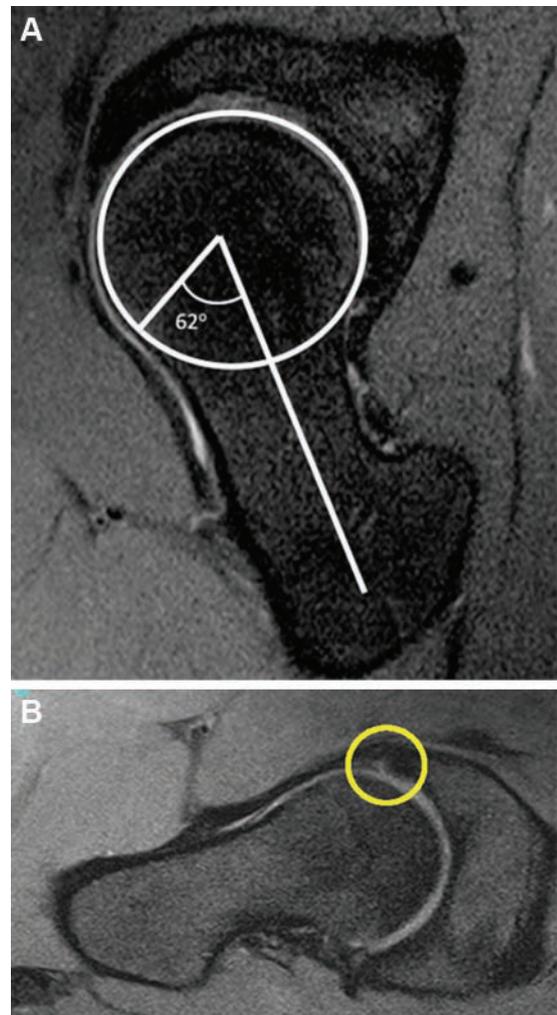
Magnetic resonance imaging scans of cam femoroacetabular impingement. (A) Depiction of an α angle. The α angle, shown here, was defined as an objective measure of the cam lesion. (B) Acetabular labral tear with partial detachment (circle).
